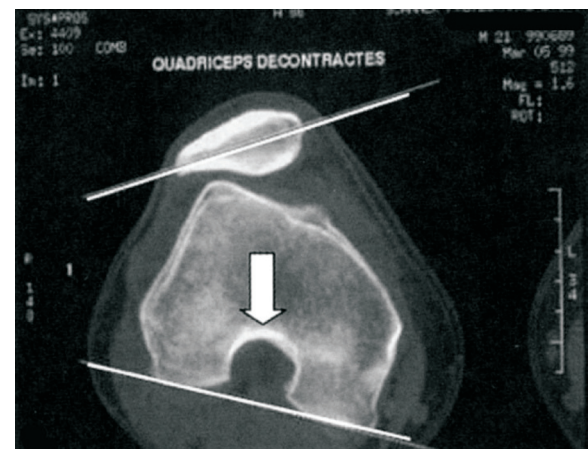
CT-Radiology image of patellar tilt.
